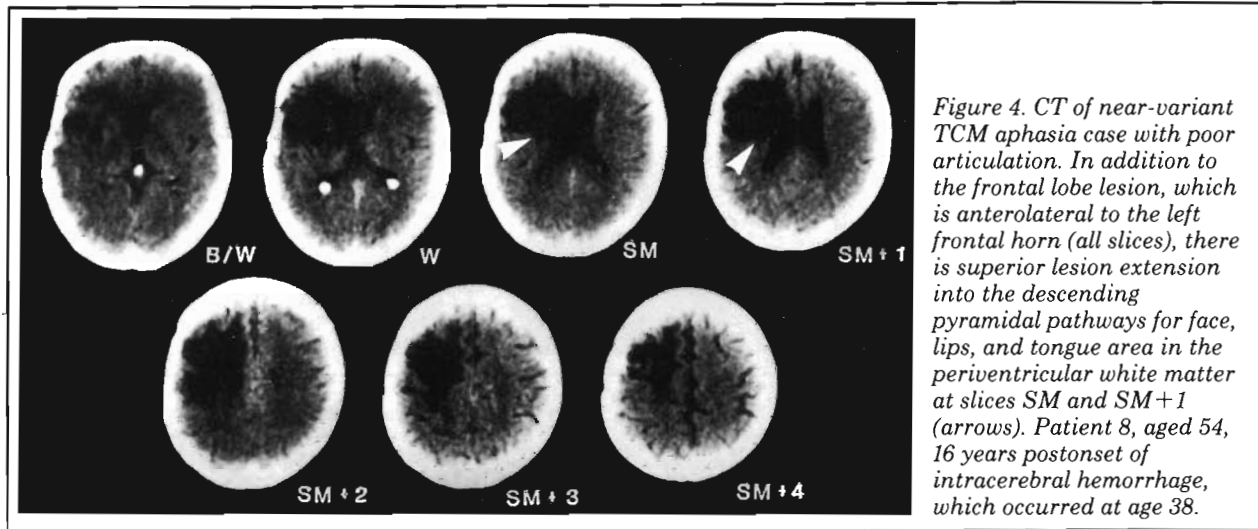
CT of near-variant TCM aphasia case with poor articulation. In addition to the frontal lobe lesion, which is anterolateral to the left frontal horn (all slices), there is superior lesion extension into the descending pyramidal pathways for face, lips, and tongue area in the periventricular white matter at slices SM and SM+1 (arrows). Patient 8, aged 54, 16 years postonset of intracerebral hemorrhage, which occurred at age 38.
